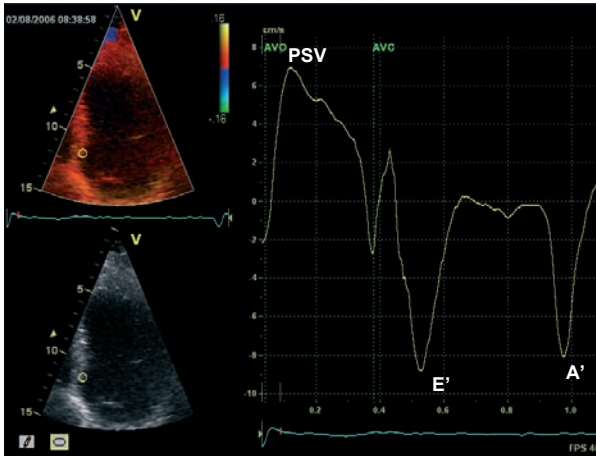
Color-coded tissue Doppler imaging in the apical 4-chamber view in a normal individual. The sample is placed off-line in the basal part of the septum, demonstrating peak systolic velocity (PSV), and diastolic parameters (E' and A'). (AVO en AVC indicate aortic valve opening and closure, respectively).
